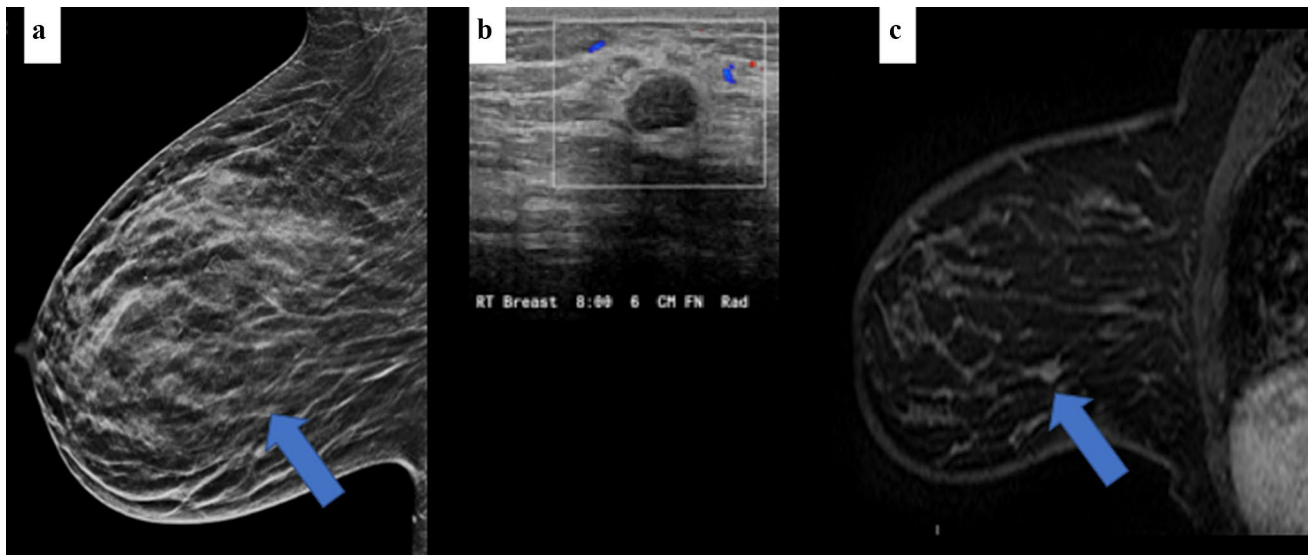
34 year-old female with a palpable right breast mass. (a) Right mediolateral oblique mammogram showing an oval mass with partly obscured margins. (b) Breast ultrasound demonstrates a circumscribed oval mass. Ultrasound biopsy was performed yielding ductal
